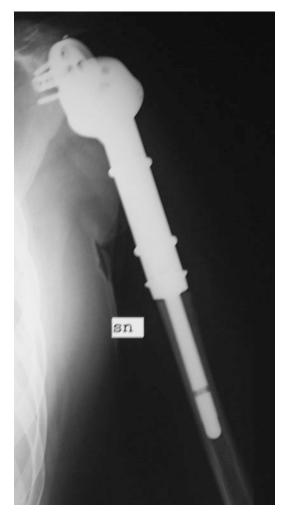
Postoperative X-ray showing reverse prosthesis reconstruction after proximal humerus resection
